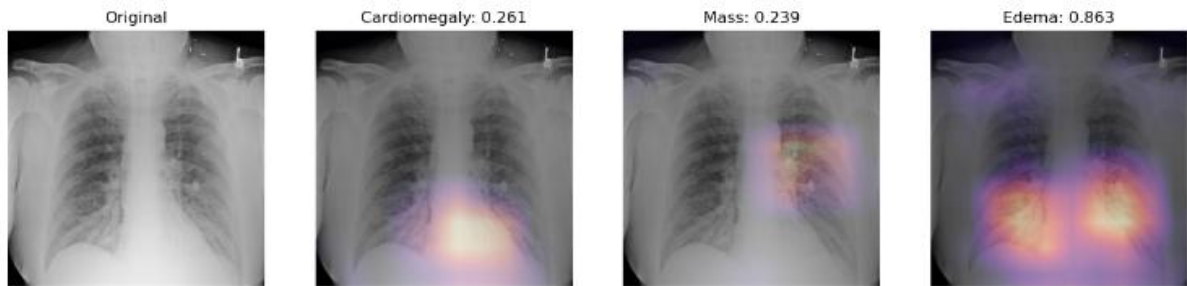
Quantum Machine Learning Based Detection of Respiratory Disease using Digital Chest X-Ray Images
